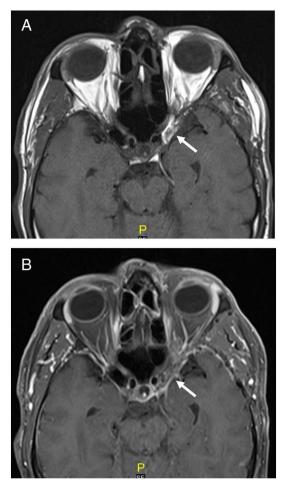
Post-operative MRI, a. axial T1, and b axial T1 fat saturated post-I.V. gadolinium contrast, showing excised mucocele, with fat packing suppressed on fat saturated images, with no abnormal enhancement (arrow in a, and b).
